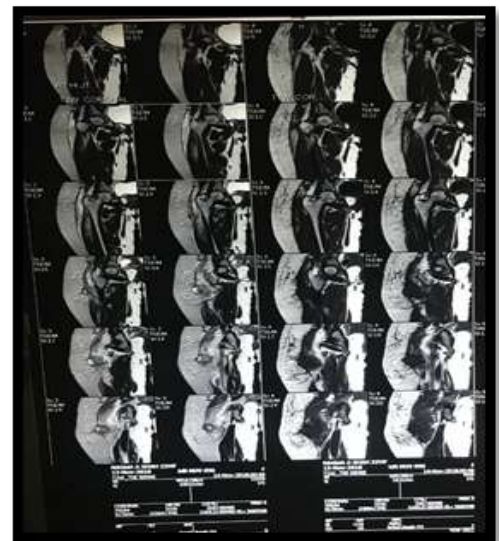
MRI T1 & T2 coronal
